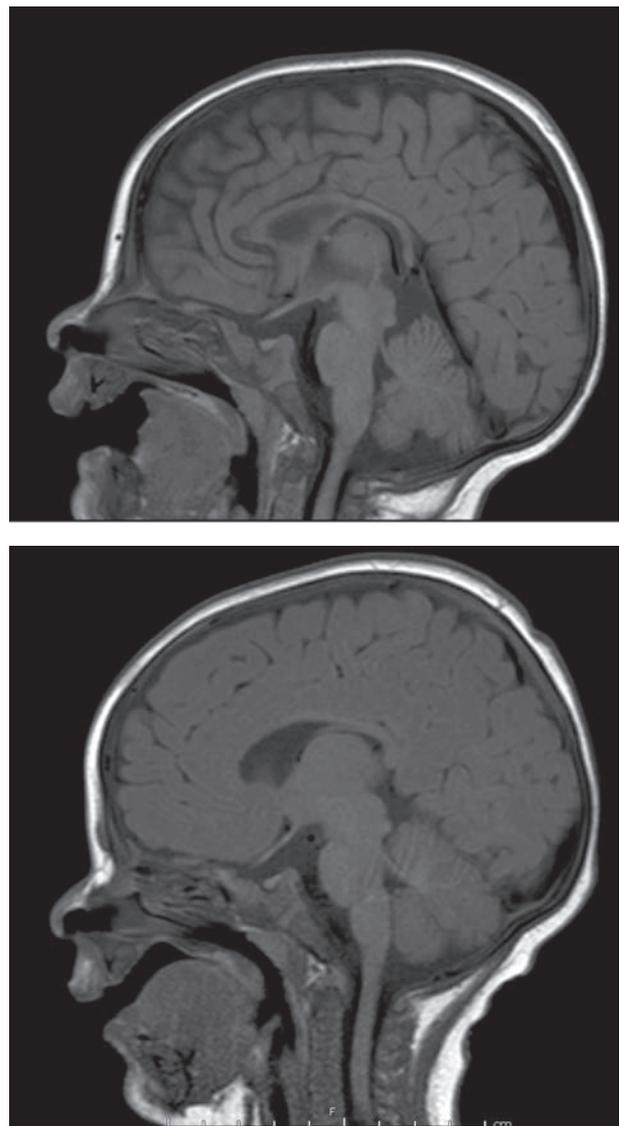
Brain MRI imaging at admission (1a) at the end of the antibiotic treatment (1b).
